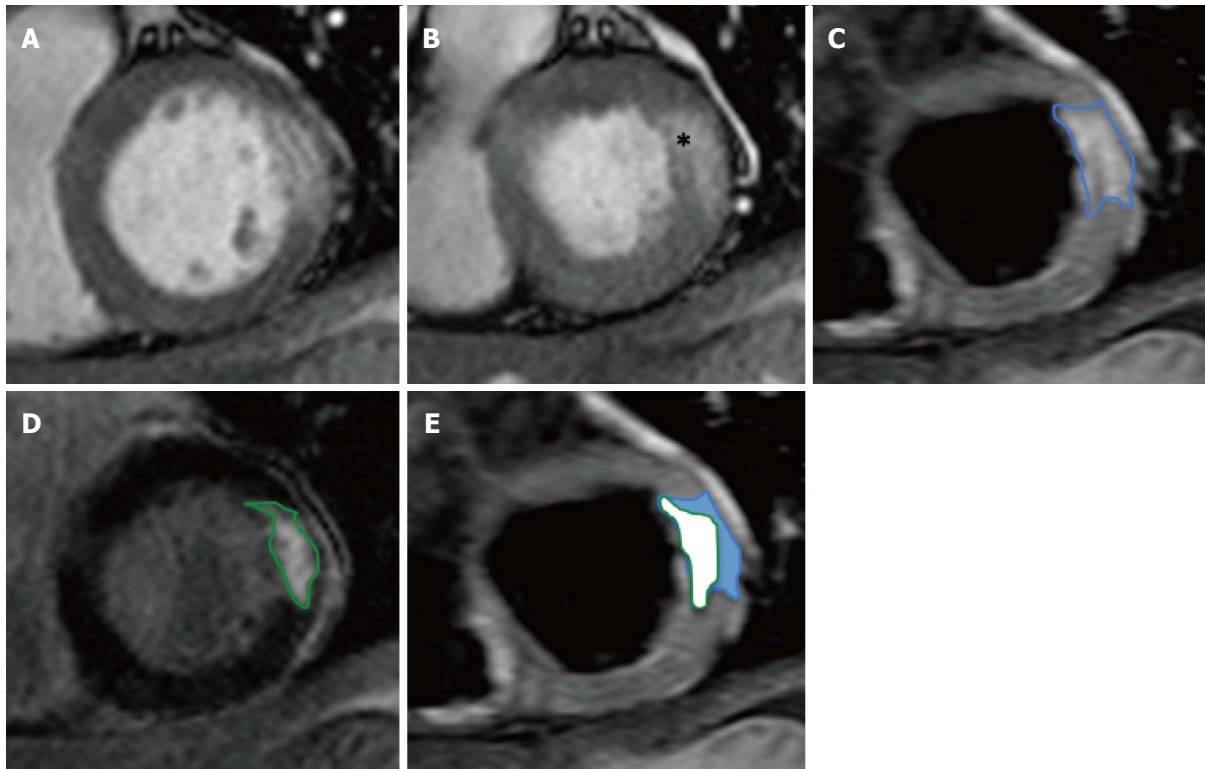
Calculation of salvaged myocardium. A: SSFP end-diastolic cine image; B: SSFP end-systolic cine image showing hypokinetic basal anterolateral segment (*); C: T2w-STIR image showing oedema (AAR) in anterolateral wall consistent with circumflex artery occlusion; D: Corresponding LGE image with near-transmural infarction; E: Calculation of salvaged myocardium in blue. SSFP: Steady-state free precession; T2w-STIR: T2-weighted short-tau inversion-recovery sequence; LGE: Late gadolinium enhancement.
